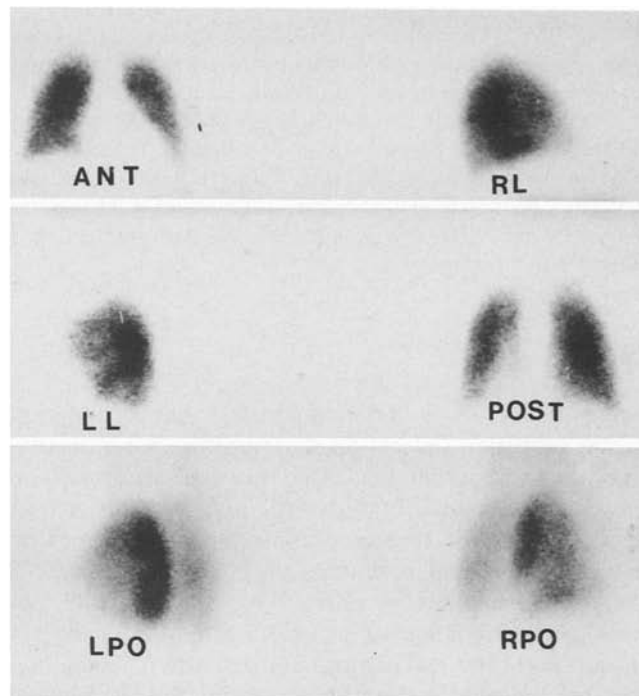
^{99m}Tc -MAA scintigram obtained 1 year after conservative treatment, demonstrating improved perfusion. Segmental and subsegmental perfusion defects are still visible in both the left and the right lower lobes. *ANT*, anterior; *POST*, posterior; *RL*, right lateral; *LL*, left lateral; *RPO*, right posterior oblique; *LPO*, left posterior oblique
